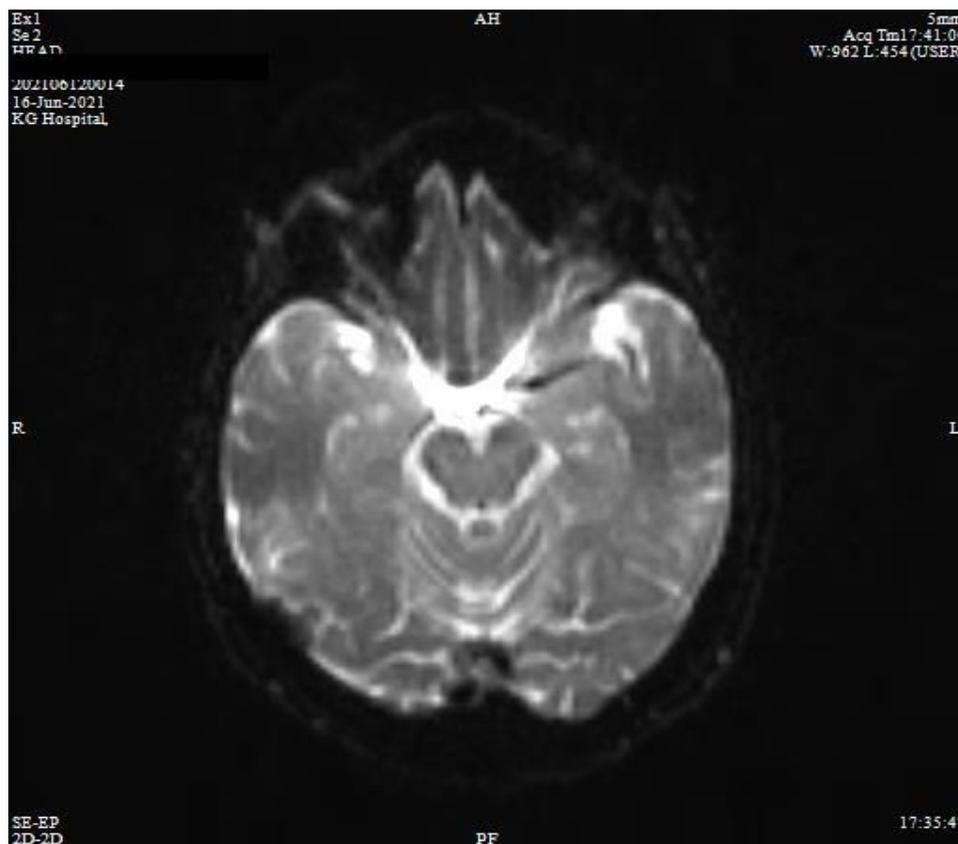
MRI showing a small focal area of diffusion restriction in right amygdala. The final impression was suggestive of autoimmune or paraneoplastic limbic encephalitis due to the presence of slightly edematous bilateral hippocampal formation.
